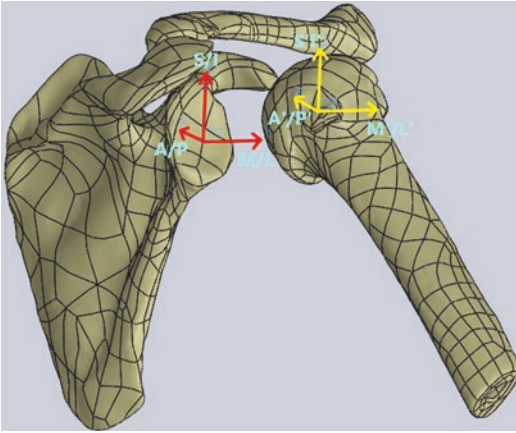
The model was created from CT scans using Materialise Mimics and imported into SolidWorks. The coordinate systems (axes) have been extracted at the approximations of glenoid surface and humeral head. (S/I denote superior inferior, M/L medial lateral, A/P anterior and posterior)
